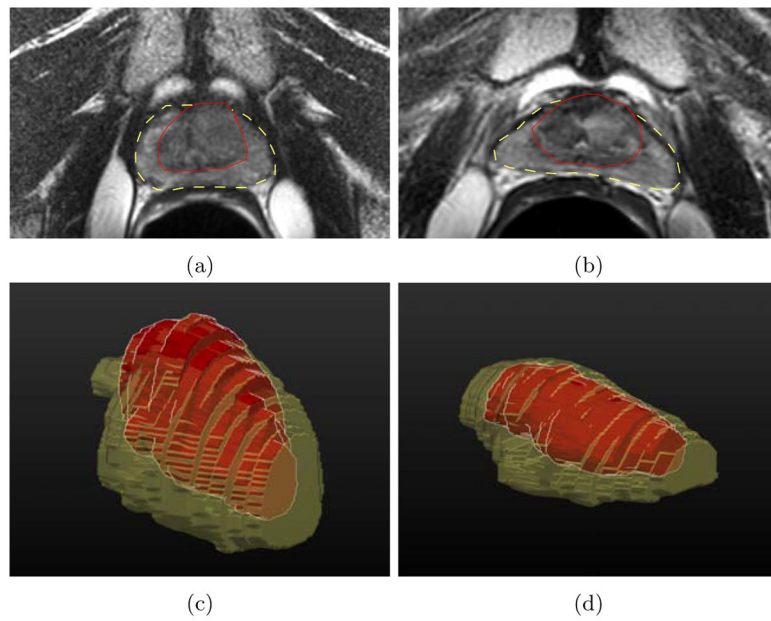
Prostate MRI intensity changes as a result of EBRT, where the PZ boundary is shown with a dotted yellow outline, and the CG boundary with a solid red outline in (a) and (b). (a) and (c) show the pre-EBRT MRI and (b) and (d) show the post-EBRT MRI. In (c) and (d) 3D renderings of the CG (red) and PZ (yellow) are shown. It can be seen that there are not only significant changes in volume to the prostate as a whole following EBRT, but also changes to the shapes of the PZ and CG, which DoCD aims to model.
